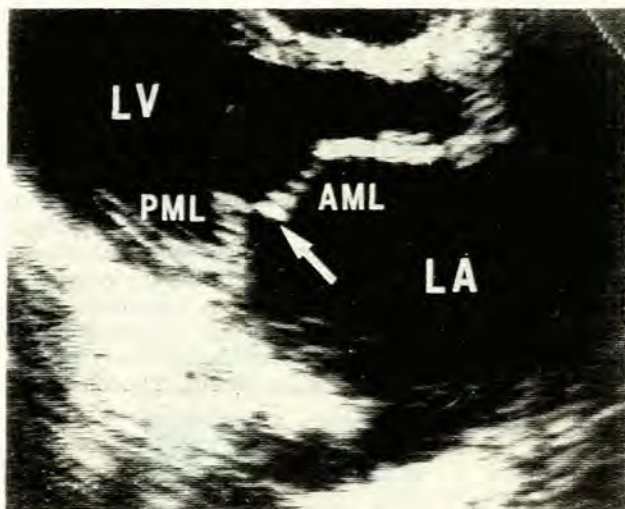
Two-D echocardiogram, in the parasternal long axis view, showing (arrow) a severely prolapsed, or flail, anterior mitral leaflet (AML) in a 10-year-old patient with fulminant rheumatic carditis and severe mitral regurgitation.
